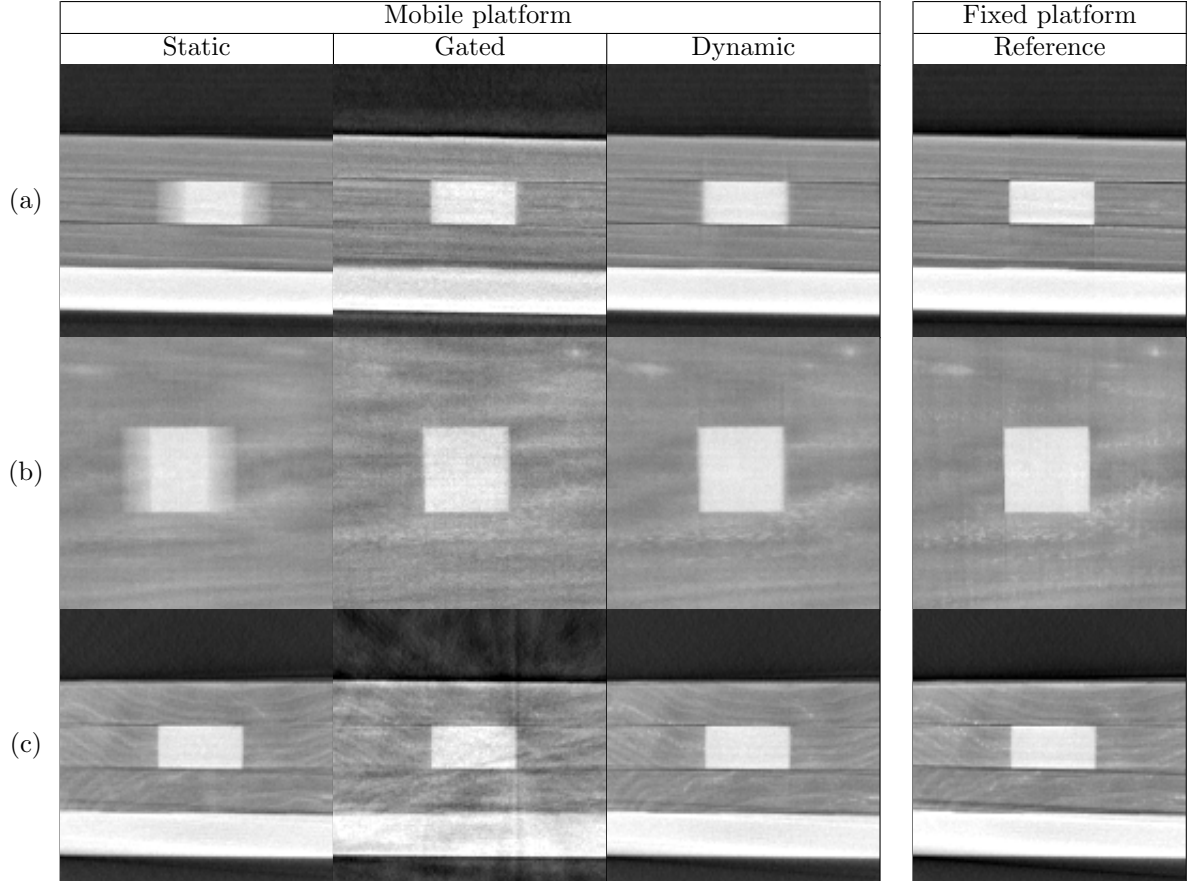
(a) Sagittal, (b) coronal and (c) transverse slices of the CT images built with static reconstruction, gated reconstruction or dynamic reconstruction from the set of cone-beam projections of the mobile platform. The reference is the CT image obtained when the platform is fixed.
